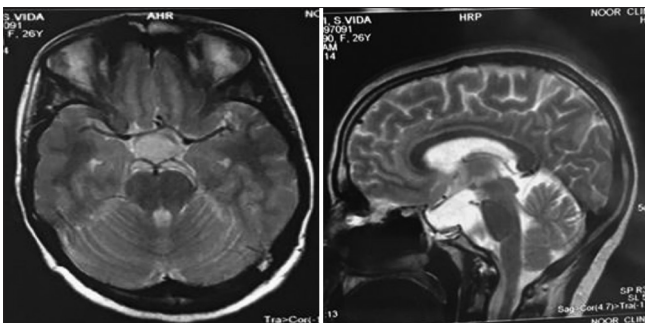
Postoperative magnetic resonance imaging. The T2-weighted axial (left) and sagittal (right) images show cyst shrinkage and decompression of brain stem
